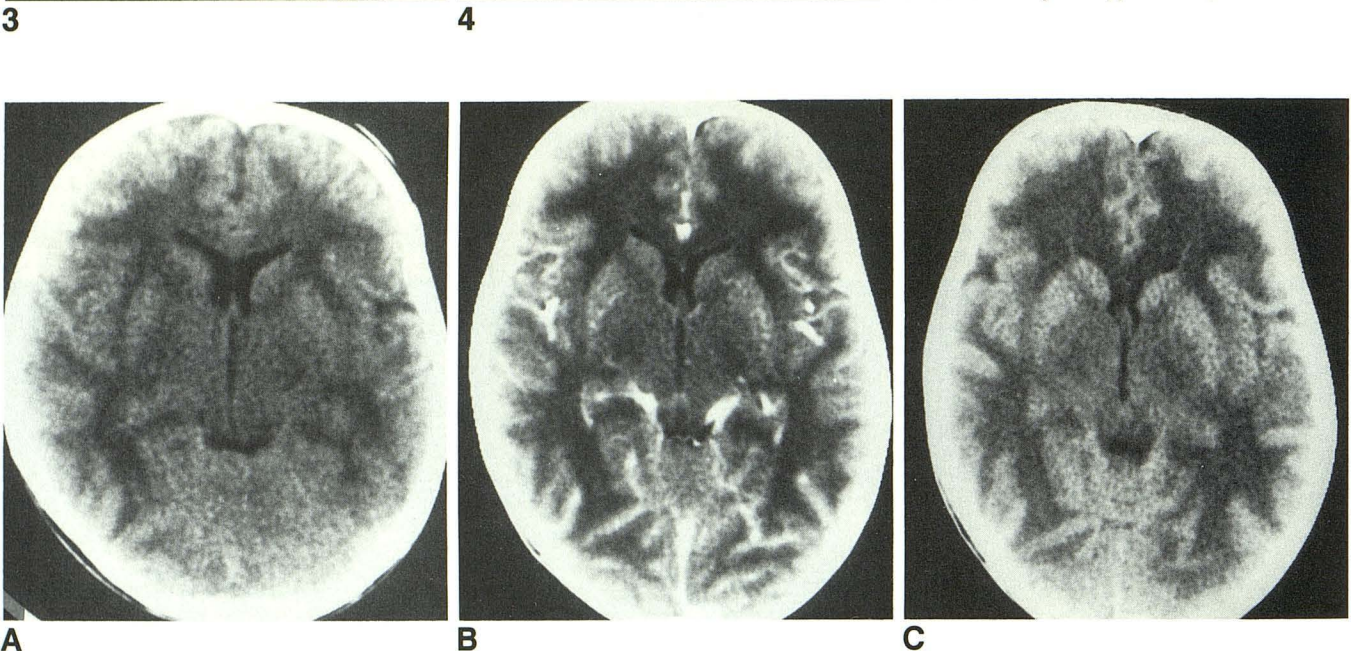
Case 3: 8-month-old mentally retarded boy with aspartoacylase deficiency, axial hypotonia, mild limb spasticity, and normal-sized head. A, CT shows marked, generalized white-matter disease; there are no signs of atrophy. B, IV contrast-enhanced CT scan at 12 months of age shows some gyral enhancement. C, CT scan at 15 months of age shows some progression of demyelination, especially in left parietooccipital region. Also note that density within globus pallidus and thalamus is somewhat reduced.
